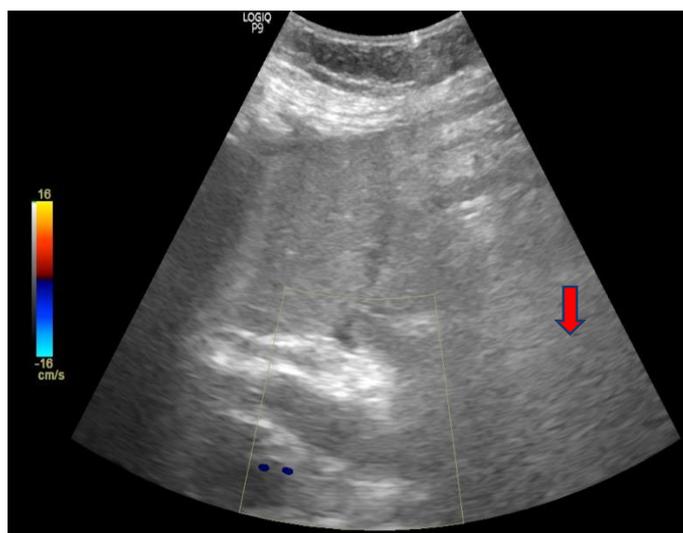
Usg abdomen colour doppler showing absent colour uptake by portal vein
